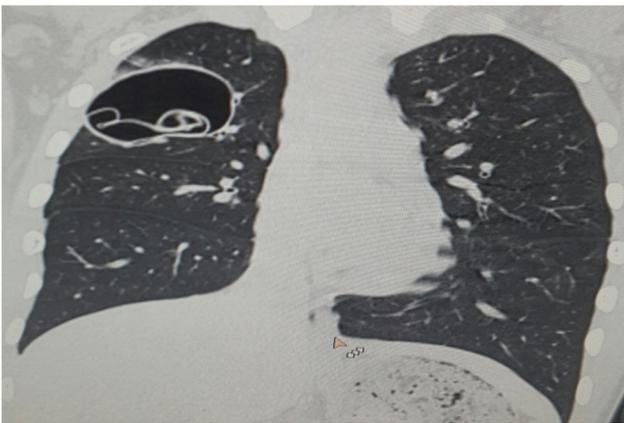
Post-aspiration CT thorax showing the serpent sign.
